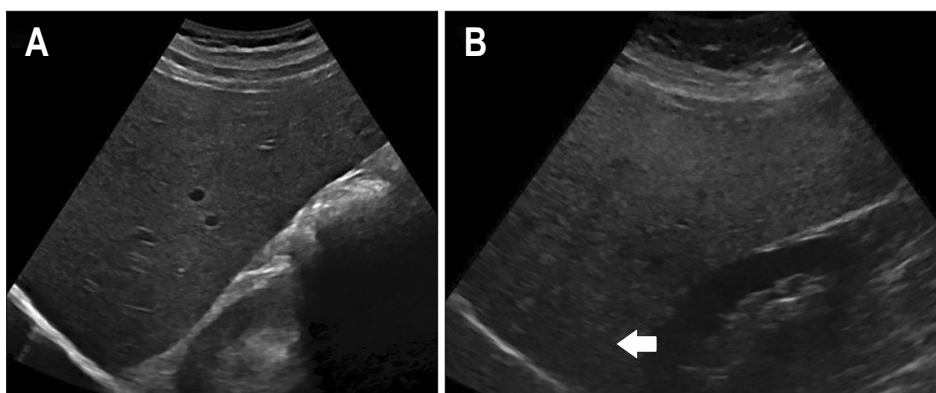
Hepatic steatosis on ultrasound (US). B-mode transverse US images of a normal liver (A) and a steatotic liver (B). A steatotic liver is diffusely echogenic with attenuation of the deeper parts of the liver.
